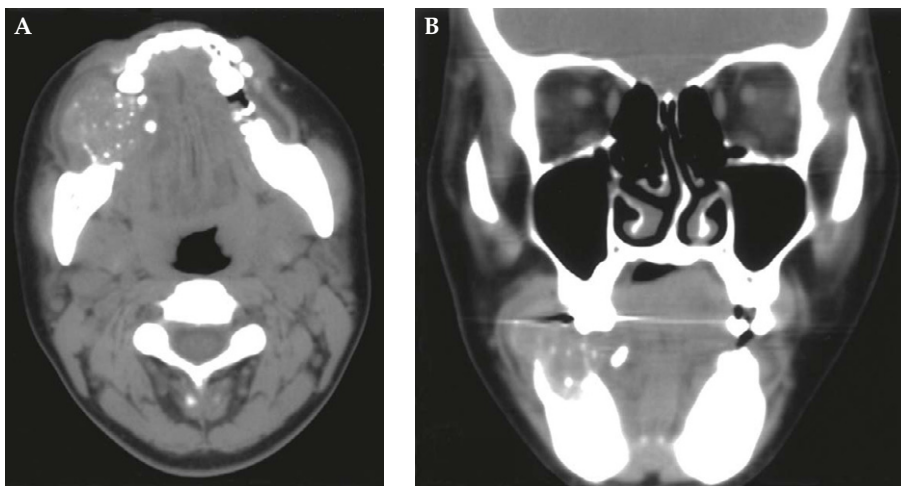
Computed tomography demonstrates a round, soft tissue mass with some calcifications in the right mandibular body and bony destruction downward to the upper third of the inferior cortical bone.
